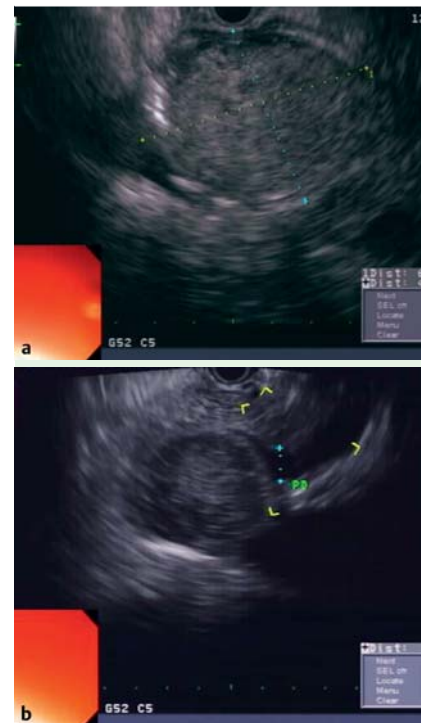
a Endoscopic ultrasound (linear view) revealing a 6 × 6-cm gastrointestinal stromal tumor (GIST). b Endoscopic ultrasound (linear view) revealing GIST-induced dilatation of the pancreatic duct to 1 cm.
